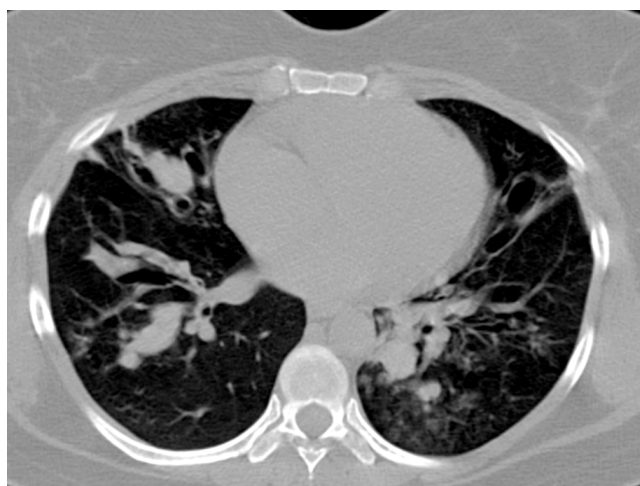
Chest high-resolution CT scan of the patient revealing bilateral bronchiectasis and mucus plugs
